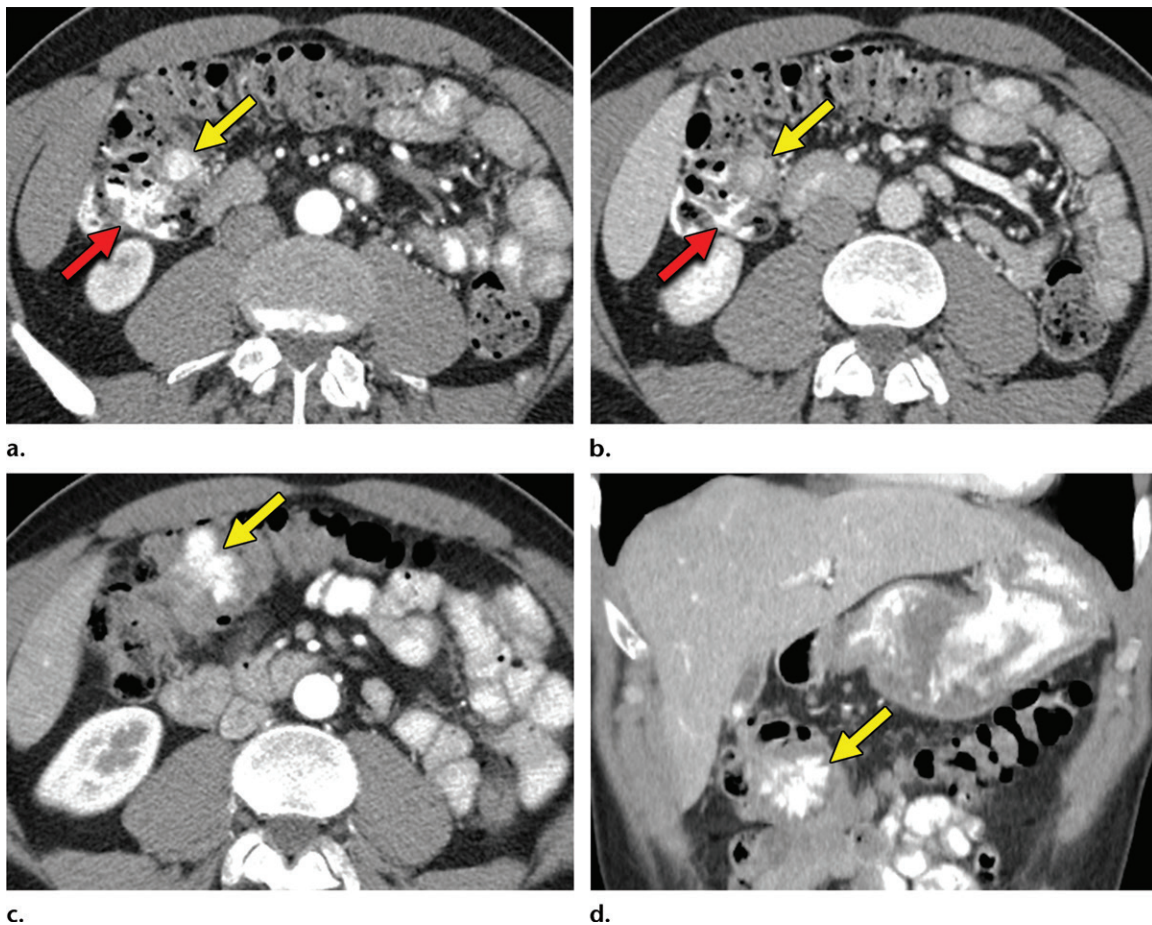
Metastatic clear cell RCC to the large bowel in a 54-year-old man. (a, b) Axial contrast-enhanced arterial phase (a) and portal venous phase (b) CT images of the upper abdomen show a subtle intraluminal lesion in the proximal transverse colon that appears nearly isointense (yellow arrow in a) compared with the oral contrast material (red arrow in a) in the adjacent colon on the arterial phase image. The lesion becomes hypointense (yellow arrow in b) relative to the oral contrast material in the adjacent colon (red arrow in b) during the portal phase acquisition. This lesion went undetected on several subsequent follow-up studies. (c, d) Axial (c) and coronal (d) CT images of the upper abdomen acquired 1.5 years later show that the intraluminal lesion has increased in size (yellow arrow) and resulted in a short-segment colocolic intussusception. Subsequent hemicolectomy allowed confirmation of metastatic clear cell RCC.
